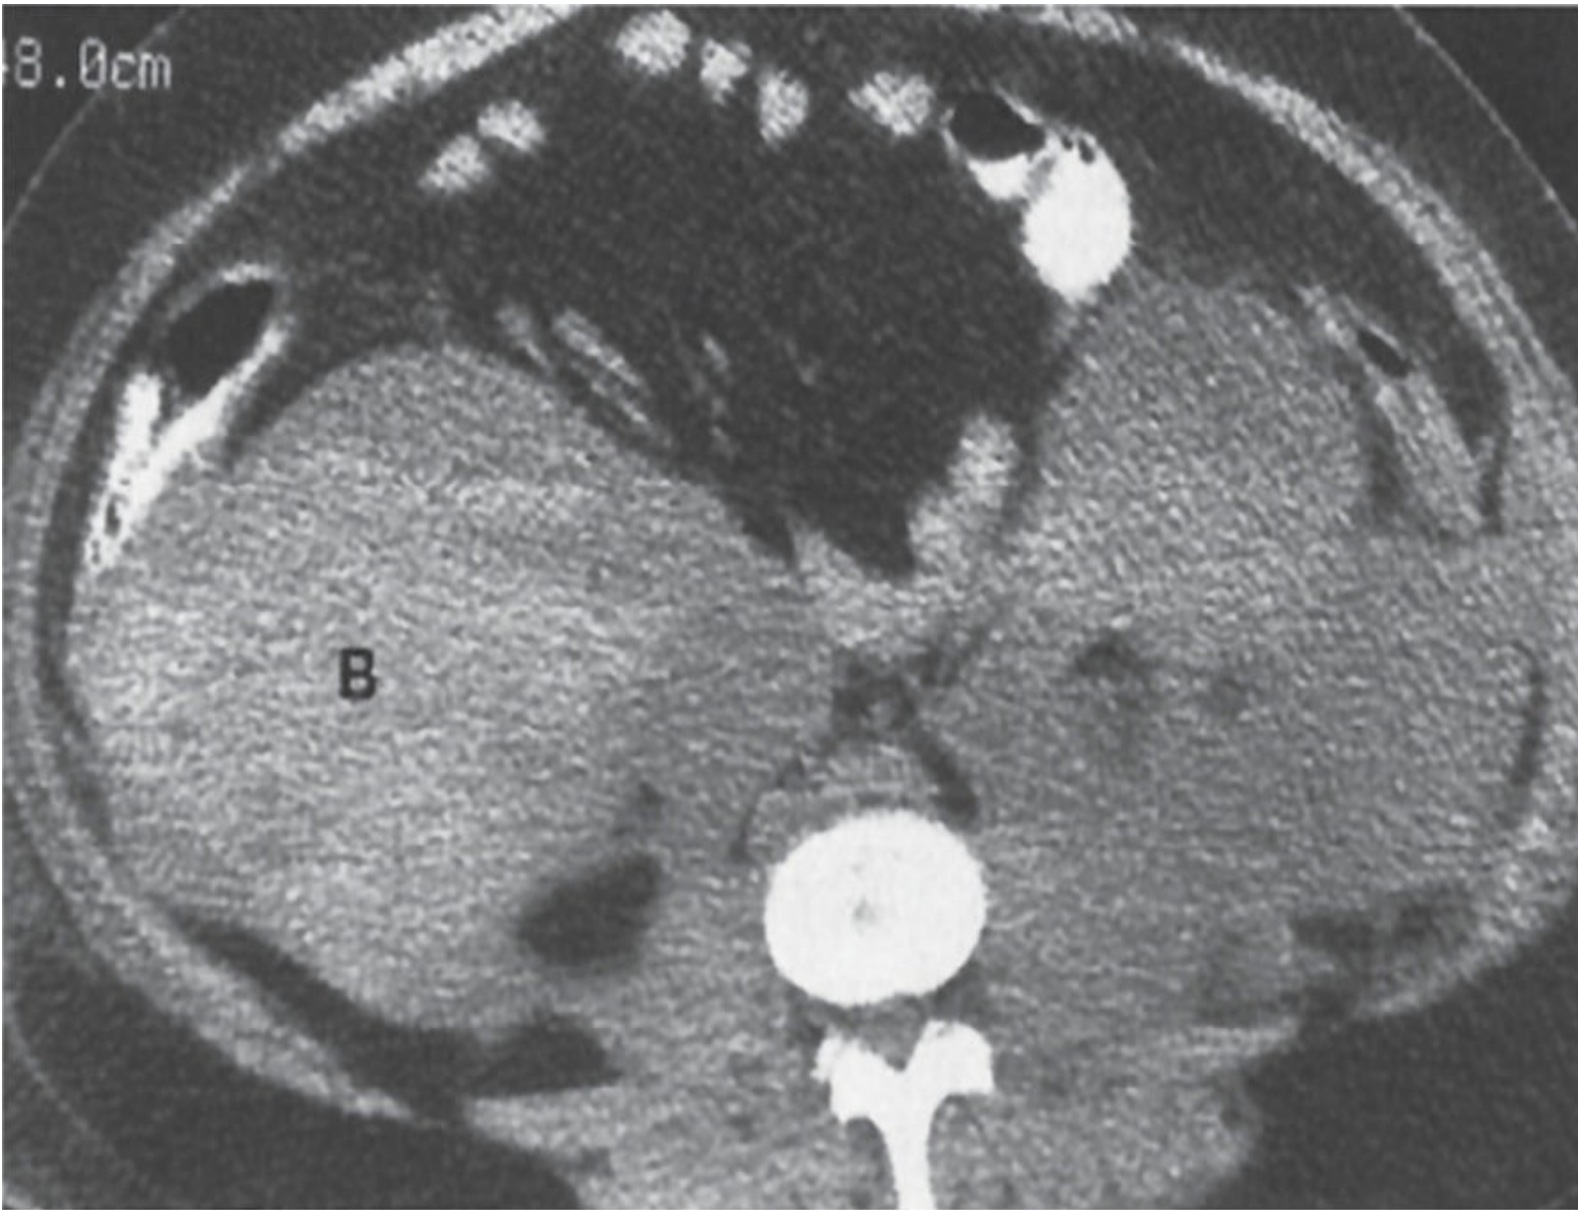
Computed tomography scan in a patient with hemorrhagic pancreatitis showing diffusely distributed pancreatic inflammatory exudate containing high-density blood (B) in the right side of the abdomen. (Reproduced, with permission, from Chen MM, Pope TL, Ott DJ, eds. *Basic Radiology*. 2nd ed. New York: McGraw-Hill; 2011.)
